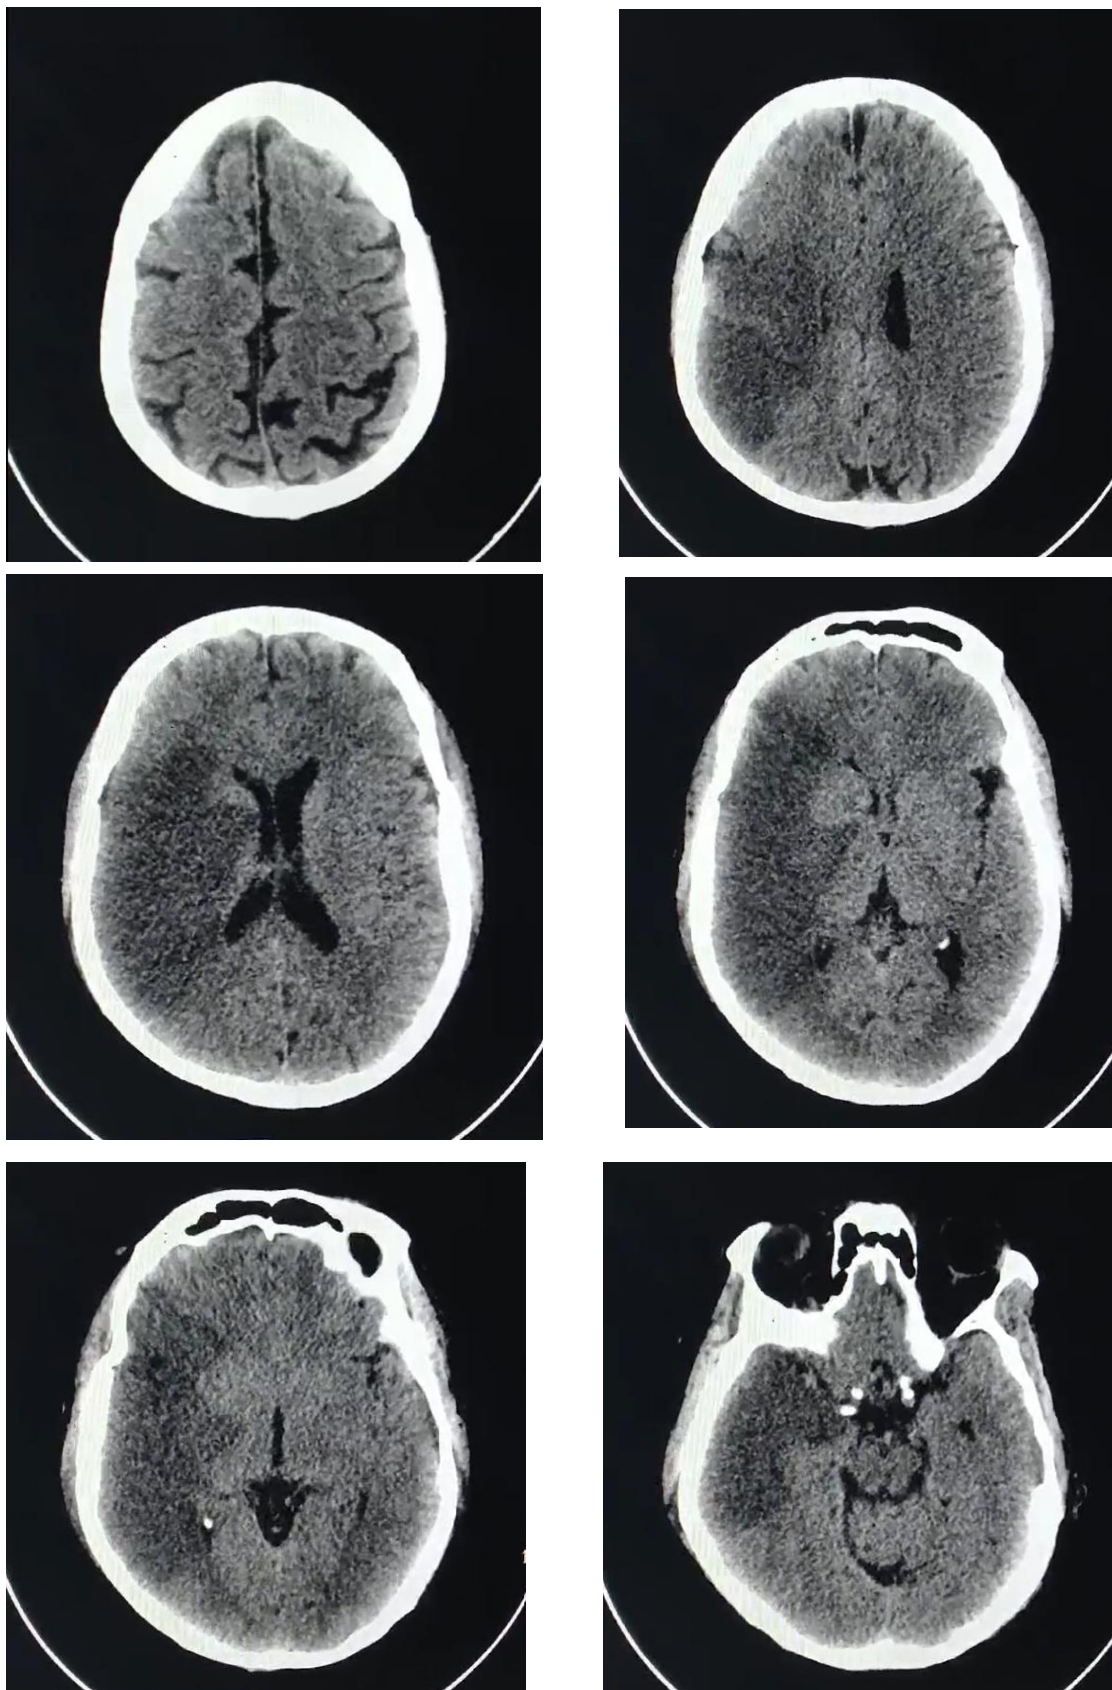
Non-contrast head CT scan on November 4, 2024, showed an infarction in the right frontotemporoparietal region
